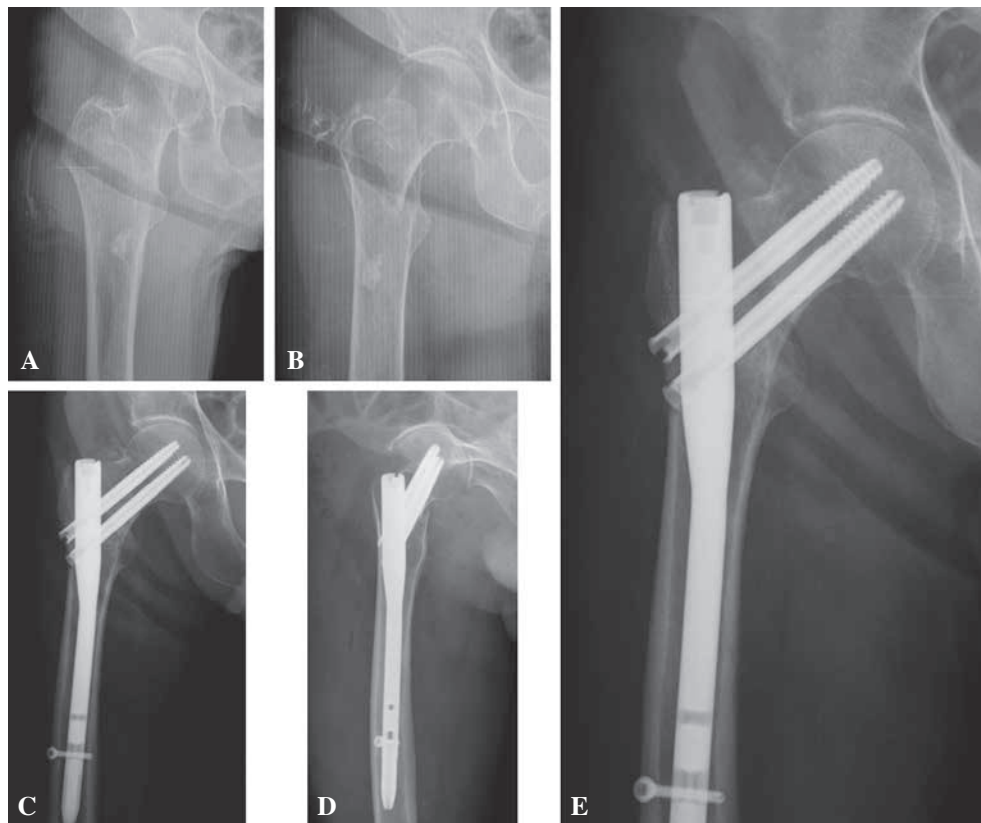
A 88-year-old female patient with a right basicervical femoral fracture : 24-month follow-up. Harris hip score = 100, modified Barthel index = 100. A-B : Preoperative X-rays. C-D : Early postoperative X-rays. E : Postoperative X-ray at 24-month follow-up.
